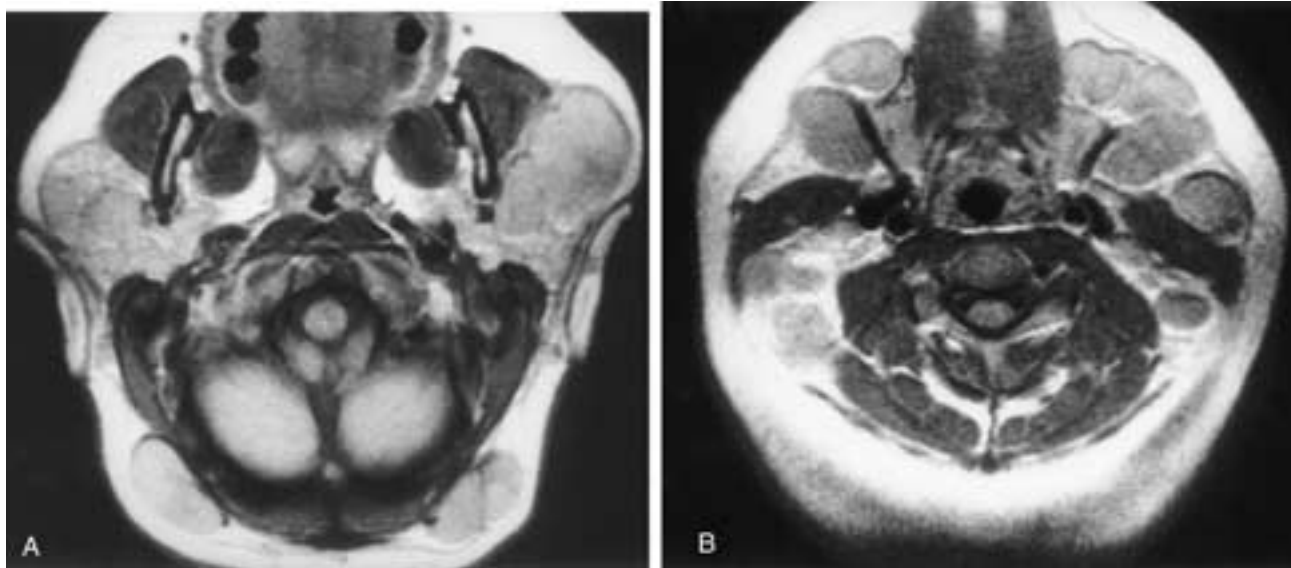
Axial T1-weighted MR images from cranial (A) to caudal (B) on a patient with sarcoidosis. There are multiple homogeneously enlarged lymph nodes in the parotid gland and in the occipital region. There are also nodes in levels I, II, and V. There was no infiltration of the adjacent fat planes. Although this imaging appearance can be seen in lymphoma, the presence of the suboccipital nodes makes a viral adenopathy or sarcoidosis more likely.
